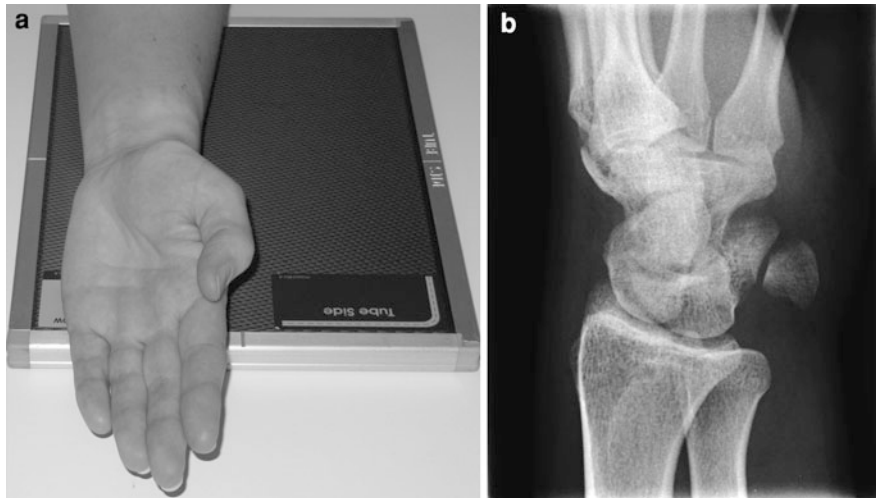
a Patient positioning for posterior oblique of carpus. b Posterior oblique radiograph of carpus
